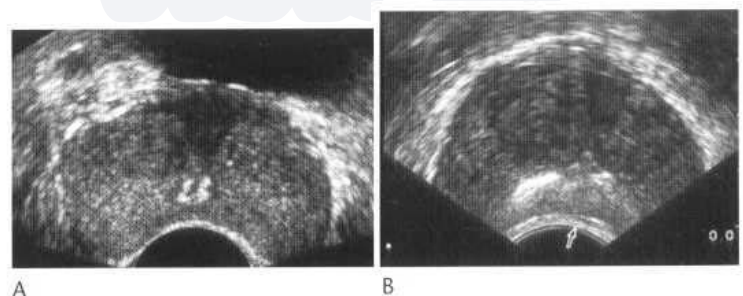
Transrectal ultrasound (transverse images) on patients with clinical prostatitis. (A) shows periurethral calcification but an otherwise essentially normal young adult gland. (B) Older patient with some benign prostatic enlargement. There is calcification at the junction of the peripheral and central gland and a slightly moth-eaten appearance to the central gland.
